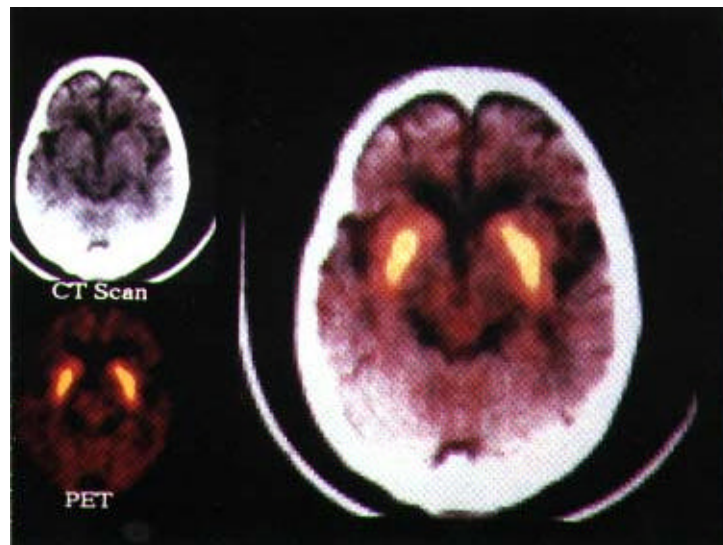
Two different images obtained by [^{18}F]Fluorodopa (FDOPA) positron emission tomography (PET) and computed tomography (CT) were overlapped at the level of the caudate nucleus and the putamen from a normal subject. FDOPA activity was symmetrically accumulated in the caudate nucleus and the putamen on both hemispheres.
